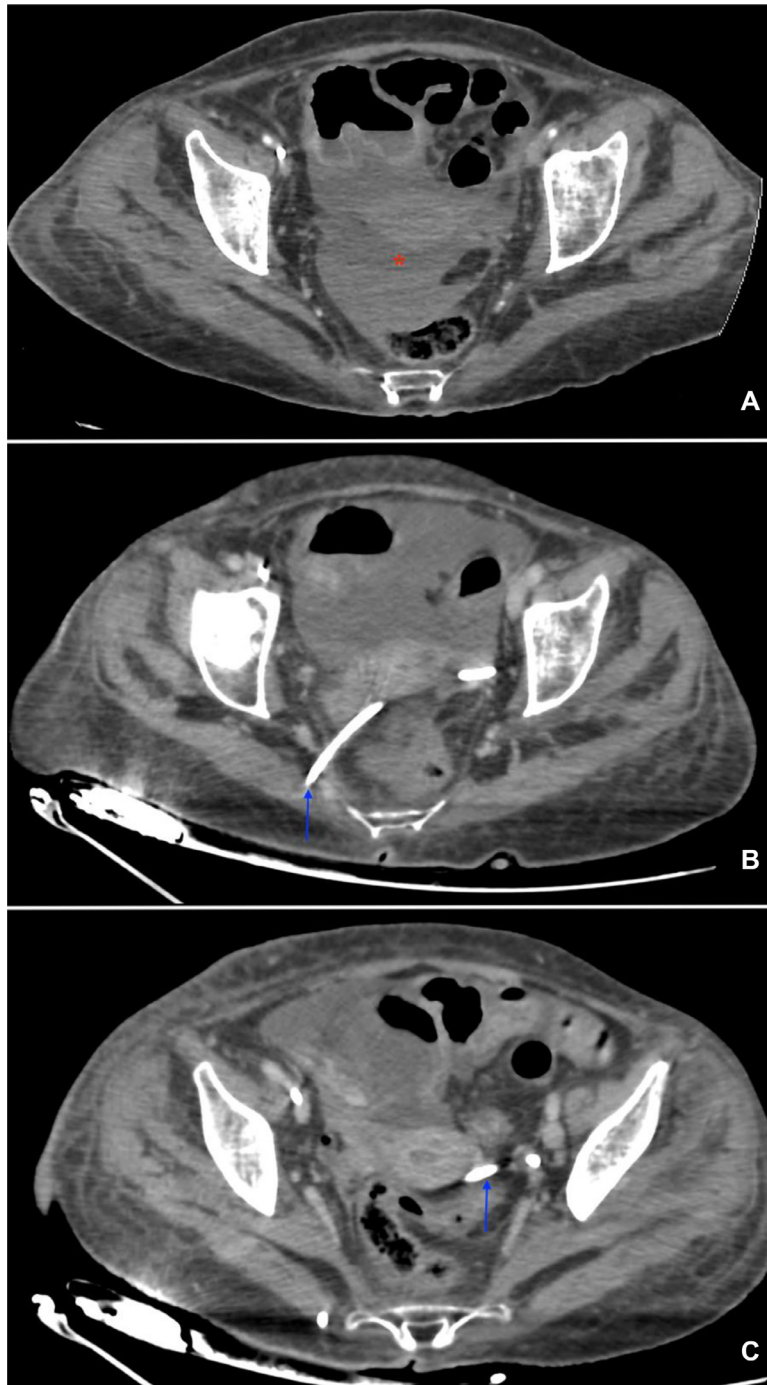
Axial CT-SCAN of our 52-year-old female patient pelvis after Intravenous contrast administration showing peritoneal fluid within the Douglas pouch (red asterisk in A). A drainage was successfully performed through a right trans gluteal approach (blue arrow showing the catheter route).
